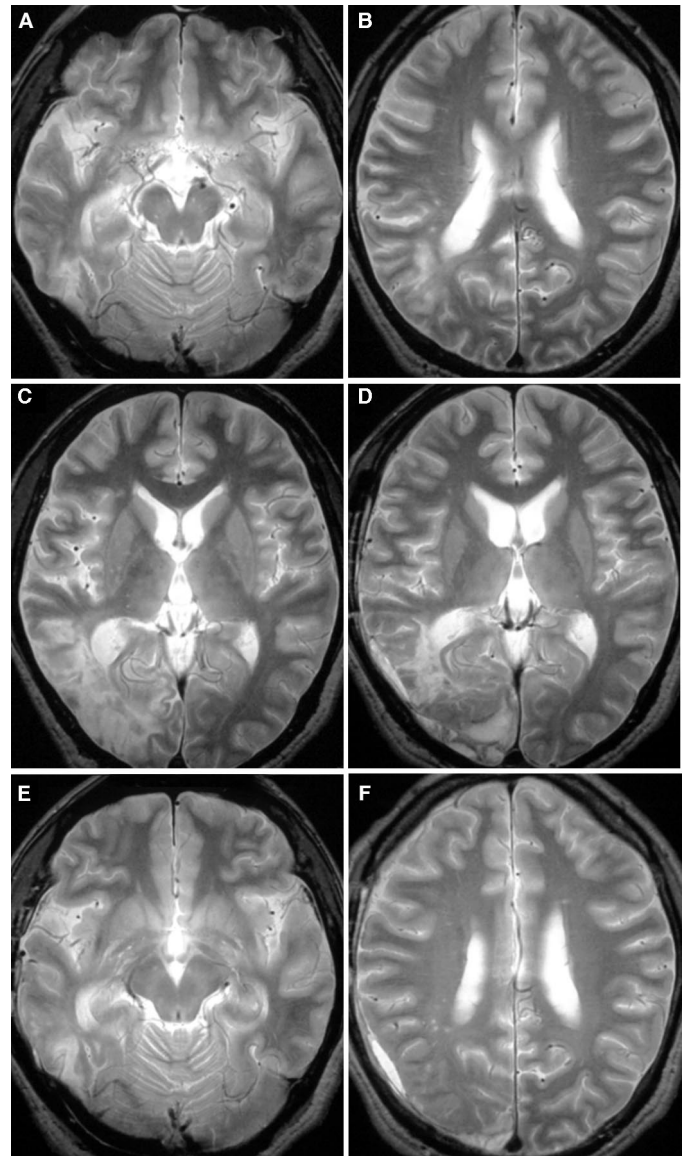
A, C, E, preoperative T2-weighted MR images showing a cerebral infarct in the right temporo-occipitoparietal region. An infarct lesion in the right occipital lobe was more extensive than that in the right temporal lobe. B, D, F, T2-weighted MR images obtained 3 months after surgery showing brain atrophy in only the right temporal lobe. The right frontal, parietal, and occipital lobes did not exhibit brain atrophy.
